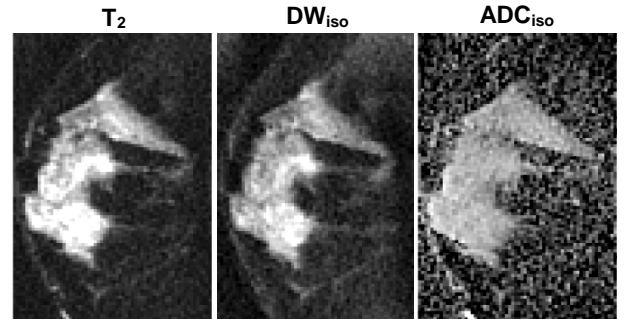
DWI of breast: 8 sagittal slices (only 1 shown here), $1.01 \times 1.01 \text{ mm}^2$ in-plane resolution, 4 mm slice thickness, 0.4 mm slice spacing, $13 \times 6.5 \text{ cm}^2$ FOV, readout in S/I direction, TE = 64 ms, b = 500 s/mm^2 , 6 min total scan time, with an 8-channel breast coil.
